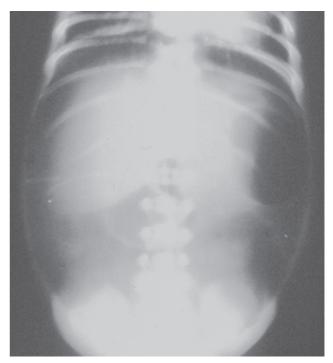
Football sign. There is a large oval lucency with a shape of an American football of massive pneumoperitoneum on supine abdominal radiograph.
